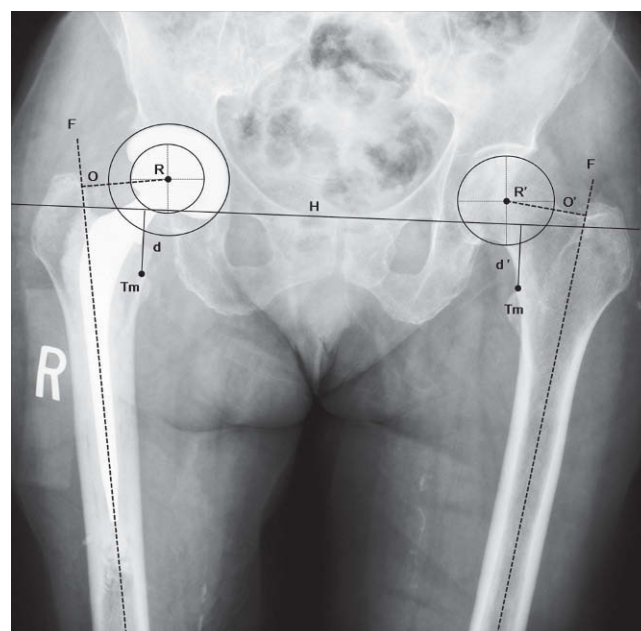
Anteroposterior pelvis radiograph showing a total hip arthroplasty (same patient from fig. 1) performed after completion of preoperative planning (table 1). It confirms the correct positioning of the components and anatomical restoration of the biomechanics of the fractured hip (centre of rotation, offset [$O = O'$] and limb length [$d = d'$]). d: vertical distance from the reference line to the proximal angle of the lesser trochanter; d': normal distance; F: femoral shaft axis; H: horizontal reference line between the two teardrop images; O: offset of the operated hip; O': normal offset; R: centre of rotation of the arthroplasty; R': hip's normal centre of rotation; Tl: lesser trochanter.
